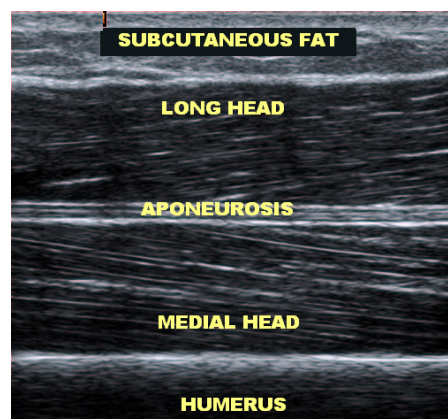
Example of an ultrasound image of the long and medial heads of the triceps brachii.
